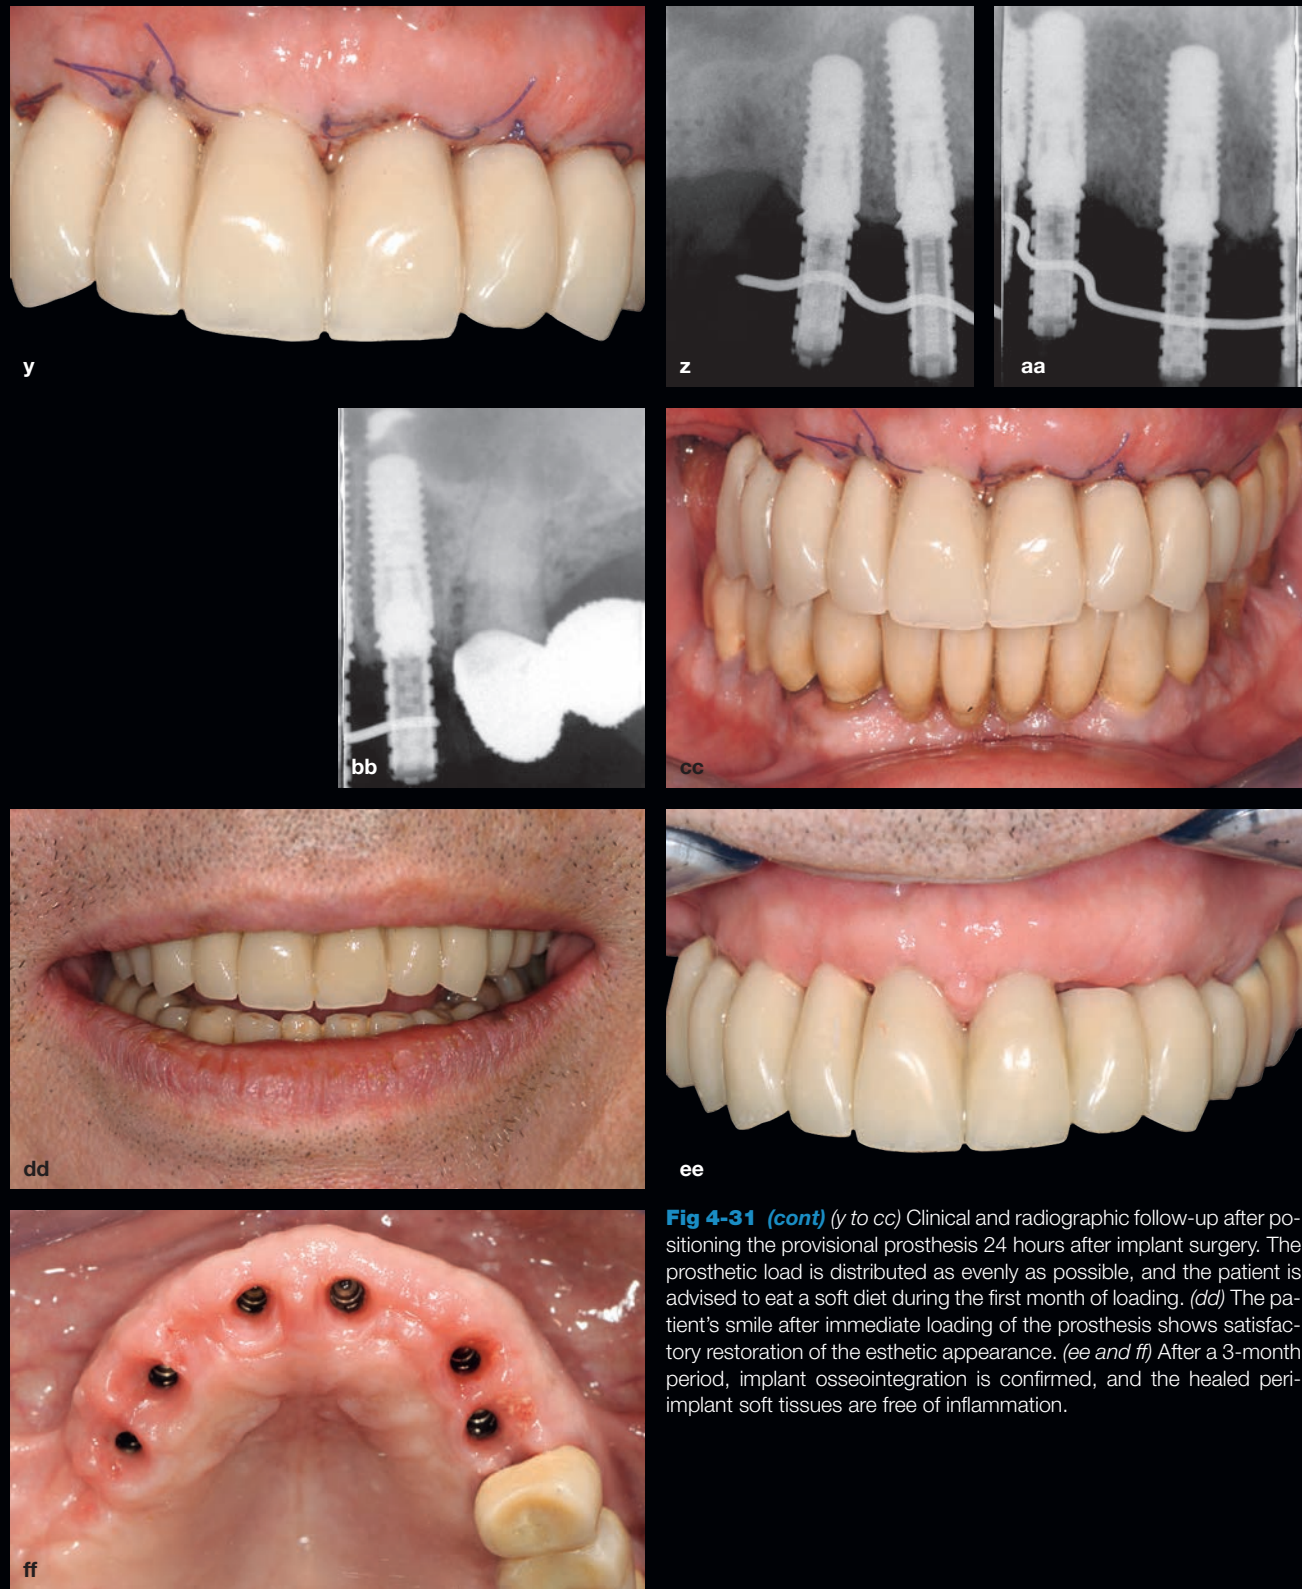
(cont) (y to cc) Clinical and radiographic follow-up after positioning the provisional prosthesis 24 hours after implant surgery. The prosthetic load is distributed as evenly as possible, and the patient is advised to eat a soft diet during the first month of loading. (dd) The patient's smile after immediate loading of the prosthesis shows satisfactory restoration of the esthetic appearance. (ee and ff) After a 3-month period, implant osseointegration is confirmed, and the healed peri-implant soft tissues are free of inflammation.
